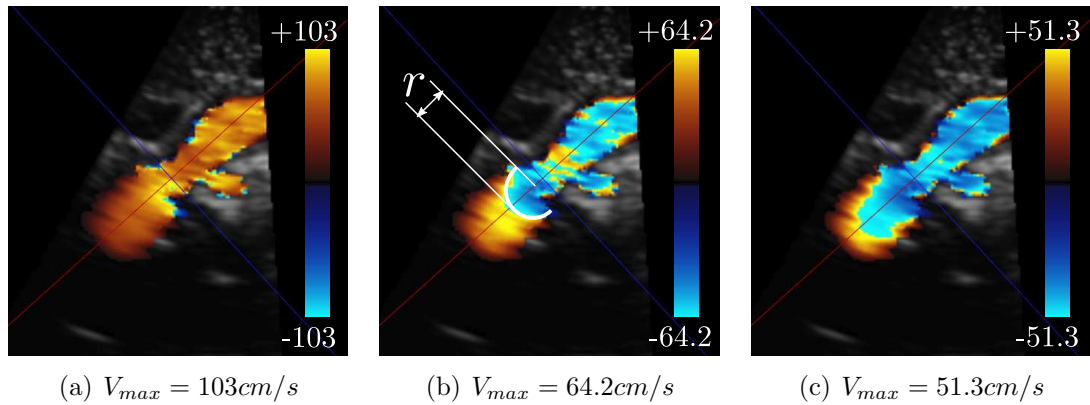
Proximal Isovelocity Surface Area (PISA) method for flow quantification through stenotic orifices. The figures show the flow through the ascending aorta in a young patient with aortic stenosis from a suprasternal view, with a decreasing Doppler velocity range ( $v_{max}$ ) from left to right. (a) The Doppler range is selected so that there is no aliasing. (b) The range has been selected so that there is some aliasing near the stenotic orifice, describing approximately an semi-circular cap. The shape of the orifice is assumed spherical and then the flow rate can be calculated as  $+64 \times 2\pi r$ . (c). The range has been selected so that there is too much aliasing occurs at too low velocities, therefore too far from the orifice where the assumption that isovelocity surfaces are spherical does not hold.
